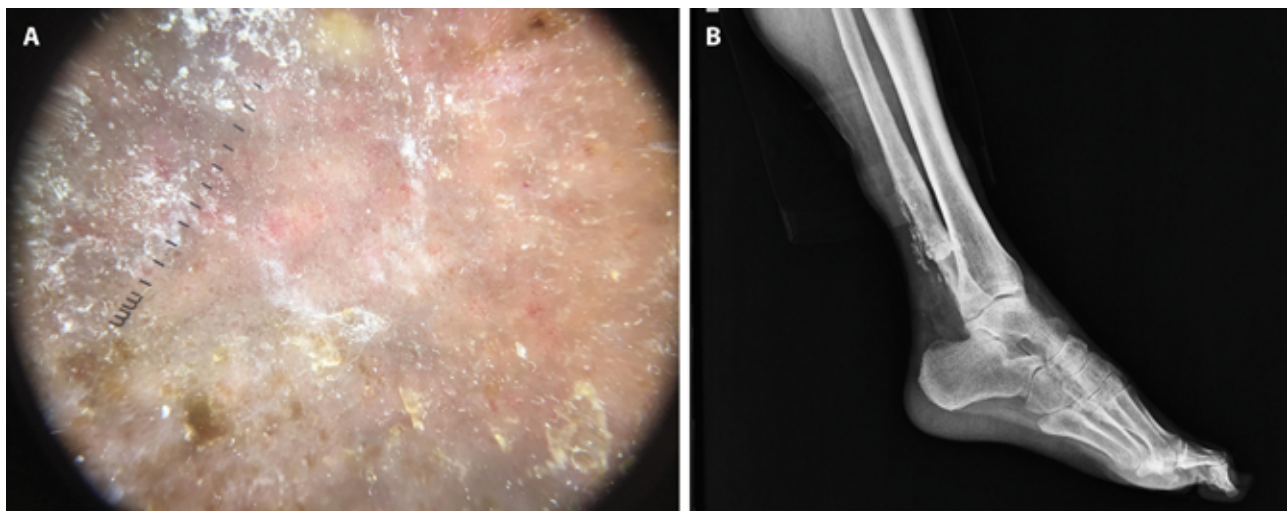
(A) Dermoscopic appearance: blue to gray structureless areas, numerous coiled vessels with patchy distribution and scale. (B) X-ray of the left lower leg showing irregular-defined calcified foci over the posterior aspect of the distal end of the fibula extending in a linear fashion.
